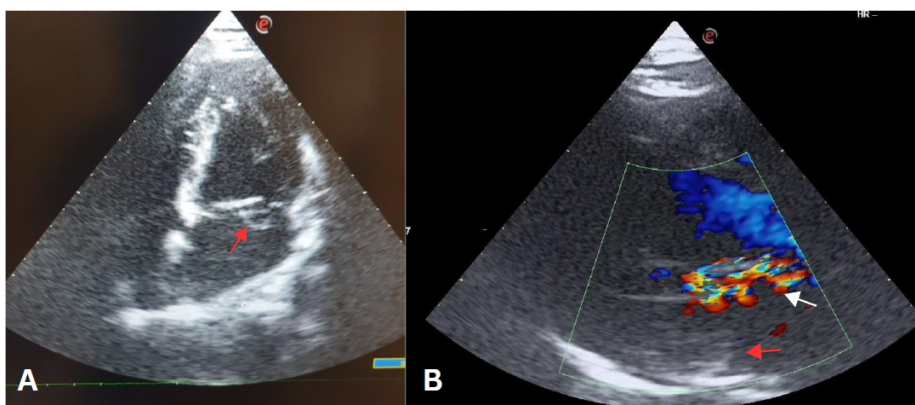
(A) TTE apical four chamber view shows a flail PML (red arrow). (B) Color-flow Doppler TTE in parasternal long-axis view shows severe MR (white arrow) and prolapsed PML to LA, consistent with chordae tendineae rupture (red arrow).
